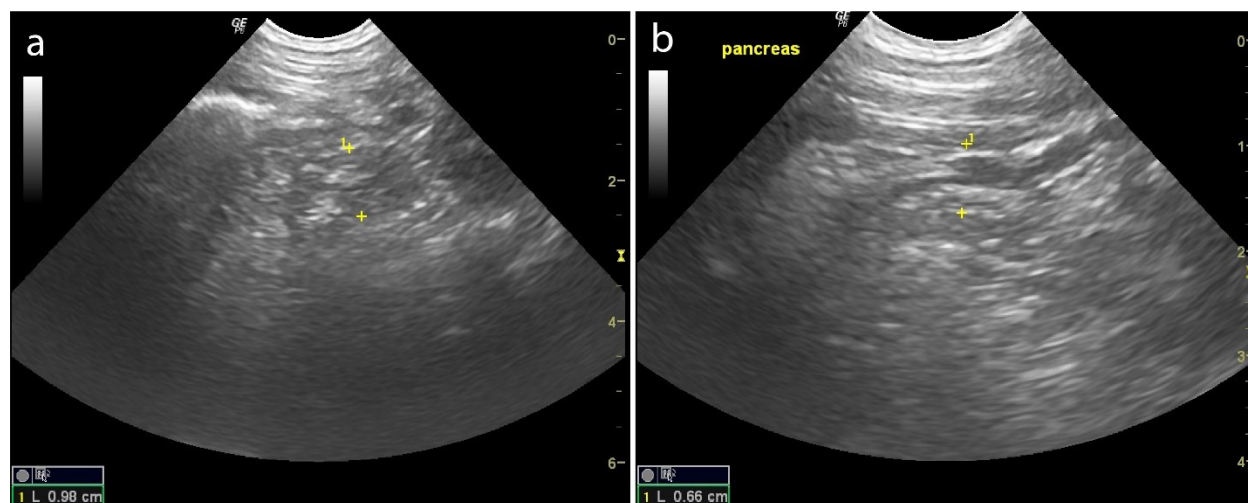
The ultrasonography of pancreas. a, heterogenous parenchyma with unremarkable of size and shape. b, heterogenous hyperechoic parenchyma compared to the previous study and no sign of inflammation of surrounding pancreatic fat.
